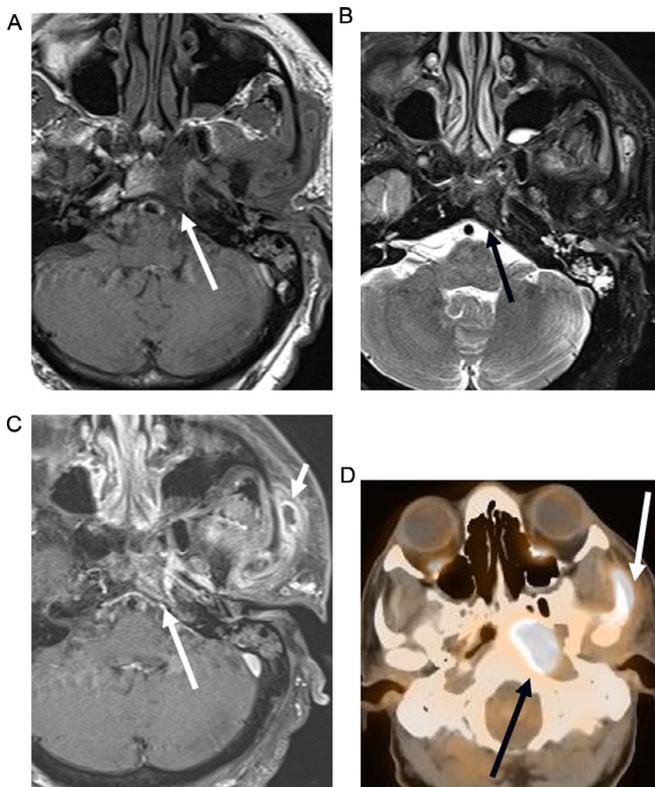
Same patient as Fig. 2. 10 weeks later, follow-up axial T1W (A), T2W (B), and postcontrast T1W with fat saturation (C) images demonstrate skull base marrow signal abnormality and enhancement (long arrows) that is nonspecific after treatment; however, residual masticator space abscess (short arrow C) is concerning. FDG-PET/CT fused image (D) shows residual infection at the skull base (black arrow) and masticator space (white arrow).
